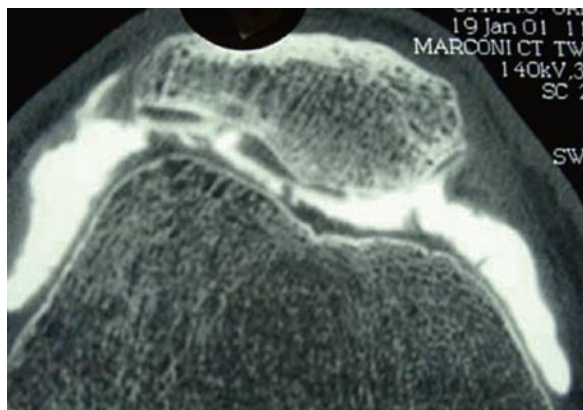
Arthro-CT is perfect exam to grade the cartilage damage; it could be coupled to all the CT scan measurement
